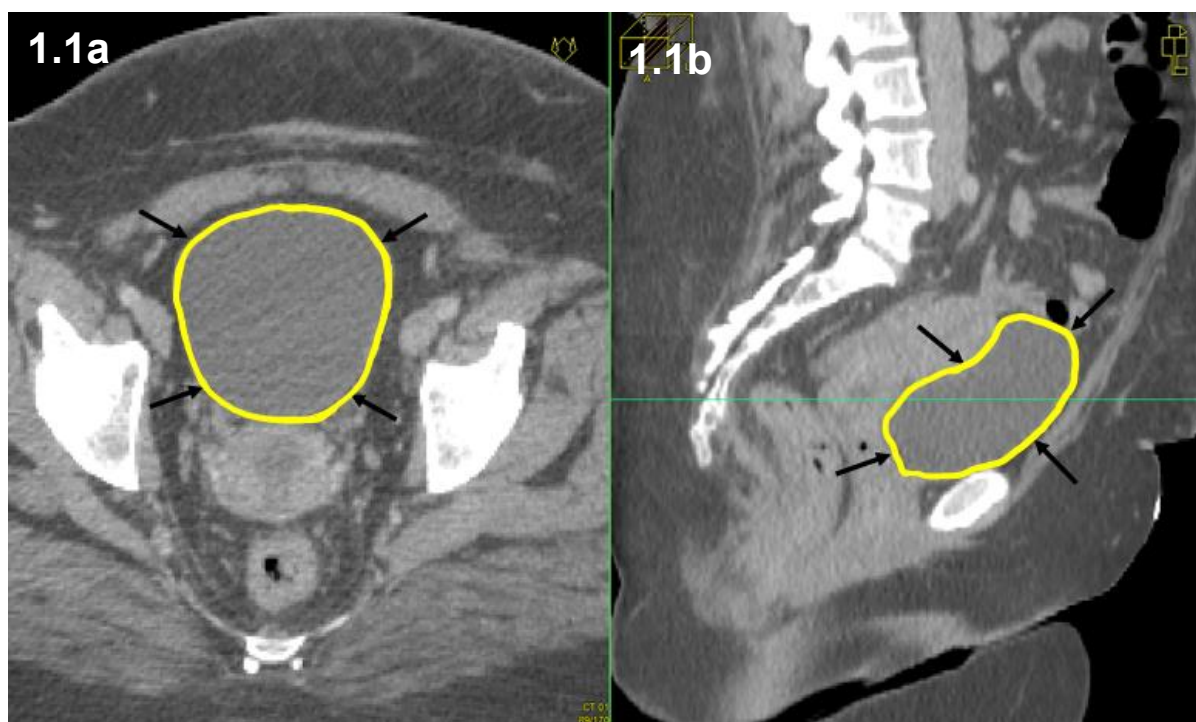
Transverse (a) and Sagittal (b) CT with bladder outlined as arrowed.
